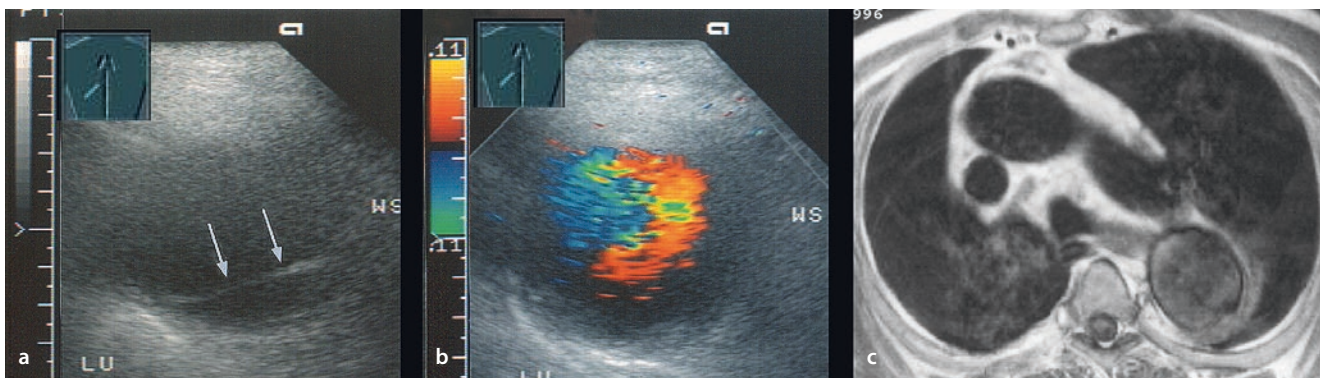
A 49-year-old man with dissection of the aorta in the chest. a The B-mode image shows an anechoic septated round lesion close to the pleura (arrow). LU lung, WS spine. b Color-Doppler
